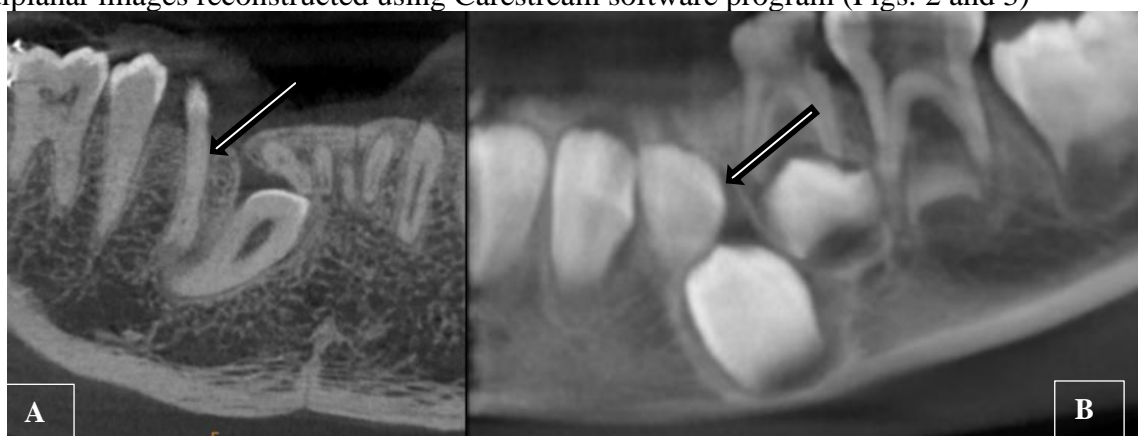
A. CBCT image of Sagittal sections (slice thickness 150  $\mu$ m) showing gubernacular canal (marked by
